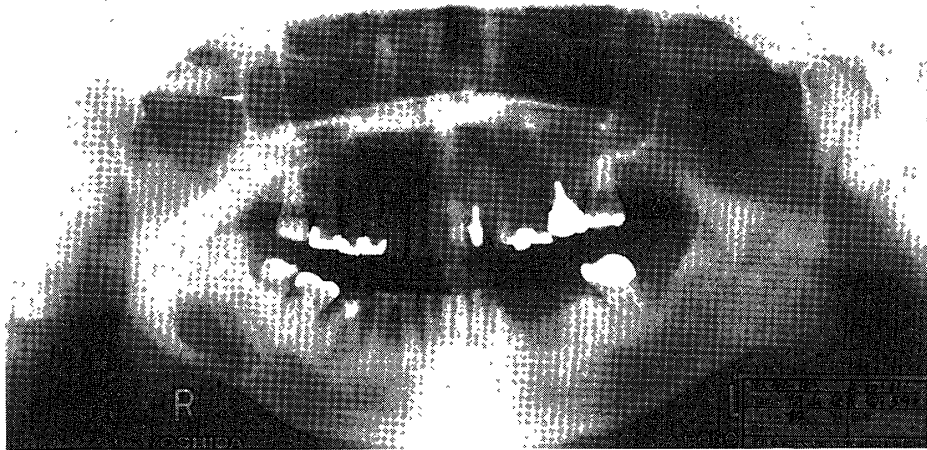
Panoramic radiograph performed by the patient's dentist, showing a well-defined radiolucent lesion near the right angle of the mandible.
